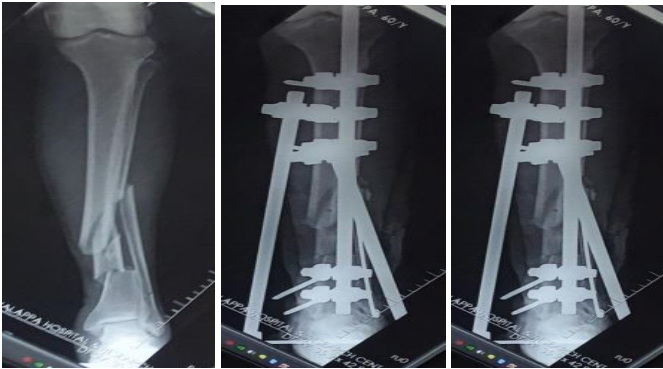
Preop x-ray AP view immediate postop x-ray AP view lateral view
